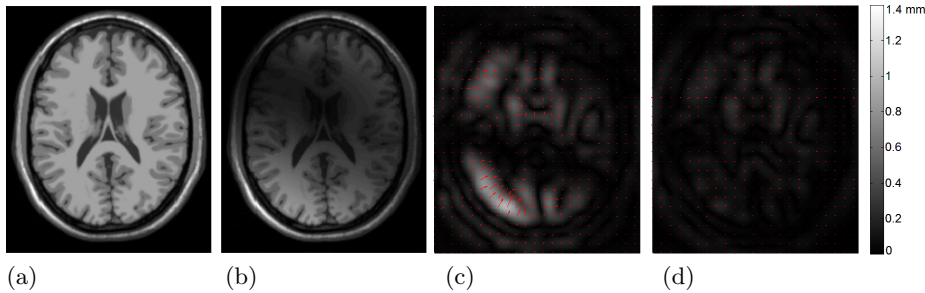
(a) T1-weighted brain image without intensity non-uniformity (INU) and (b) the INU field computed from the subtraction of (a) and the image with INU. (c) is the resultant deformation field of registering (a) to the image with INU using NMI measure and (d) is the result using the proposed registration method. The color bar indicates the displacement magnitude in (c) and (d). Brain data downloaded from BrainWeb (www.bic.mni.mcgill.ca/brainweb/)
